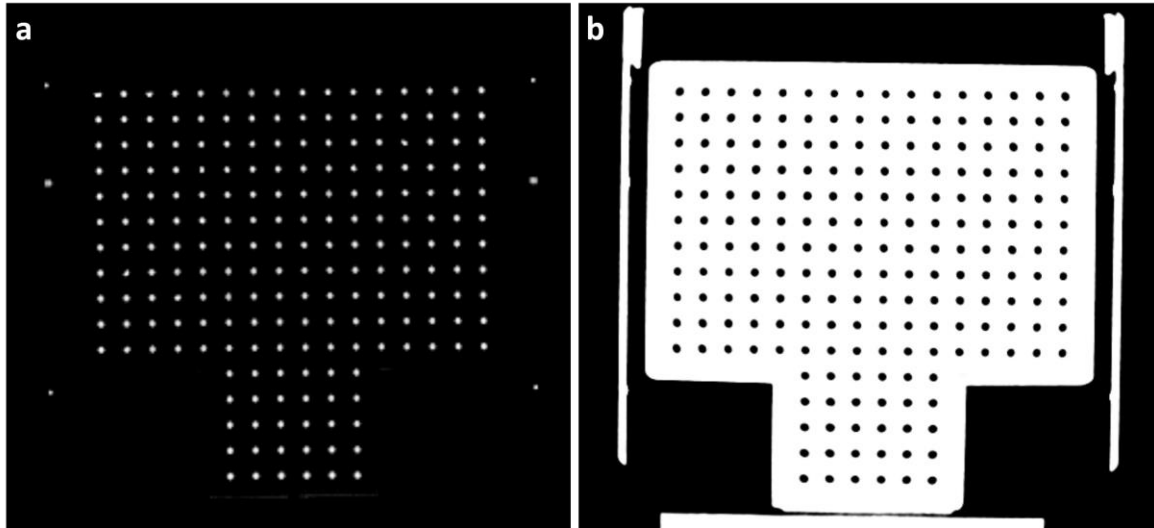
An indicative axial slice of the performed MR scan series #1 nF (a) and CT scan (b), depicting the high contrast between CPs and acrylic. The N shaped fiducials of the Leksell localization box are also visible. Presented images are not spatially co-registered.
